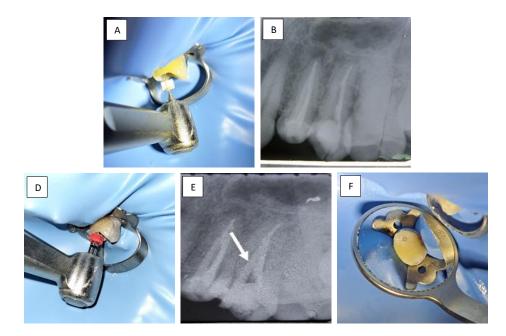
A. Gutta percha removal; B. Radiographic image of Gutta percha removal; C. Preparation with luxadrill; D. Radiographic image of fiber post installation; E. Core Making Process.
